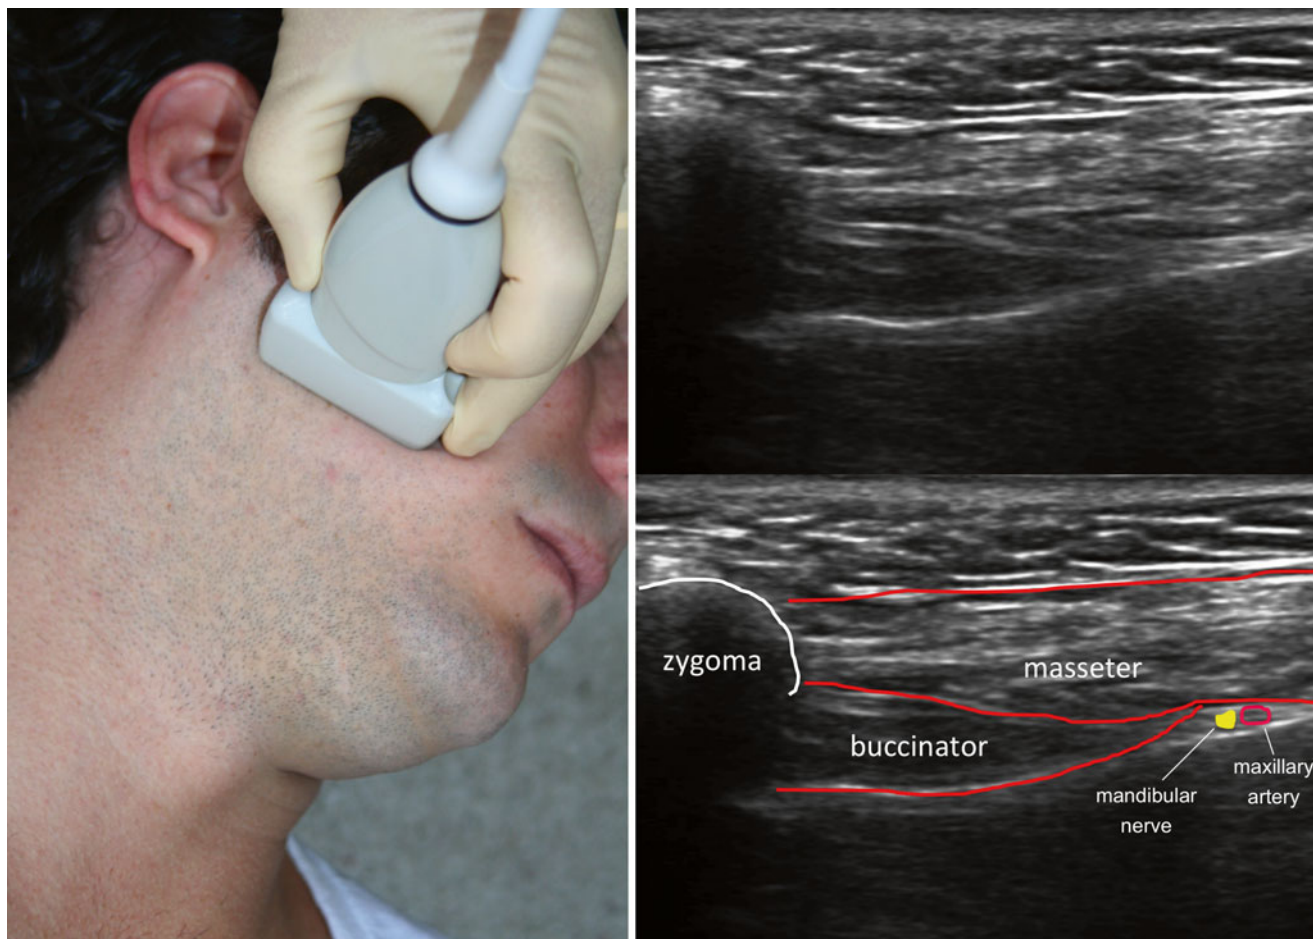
Ultrasound evaluation of the mandibular nerve (Image courtesy of Andrea Trescot, MD)
